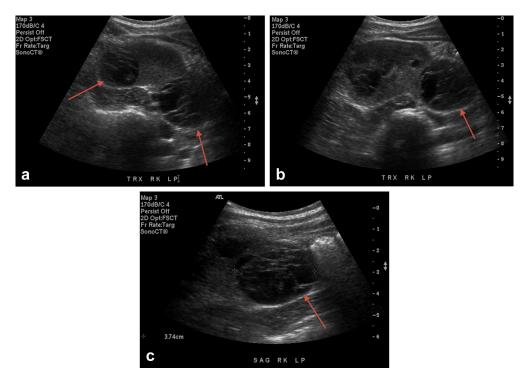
(a-c) Transverse image of the lower pole of the right kidney demonstrates multiple complex masses. These appear as complex cysts with multiple irregular solid septations in which flow could be seen on color Doppler (not included). The largest was located within the lower pole measuring 3.7×4.6 cm.
